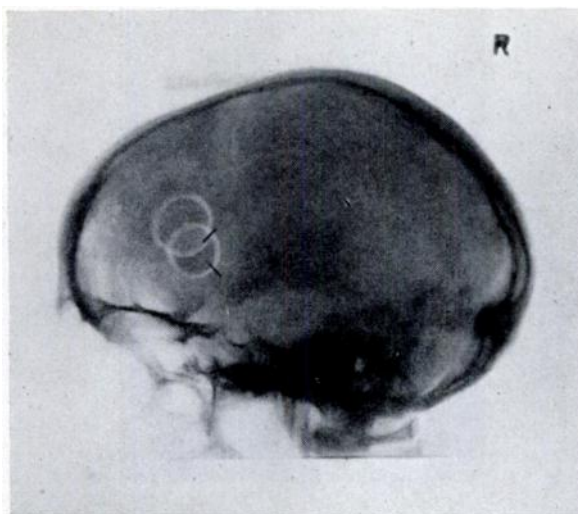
X-ray photograph, taken after operation, showing the position of the metal markers left in the leucotomy lesions.
